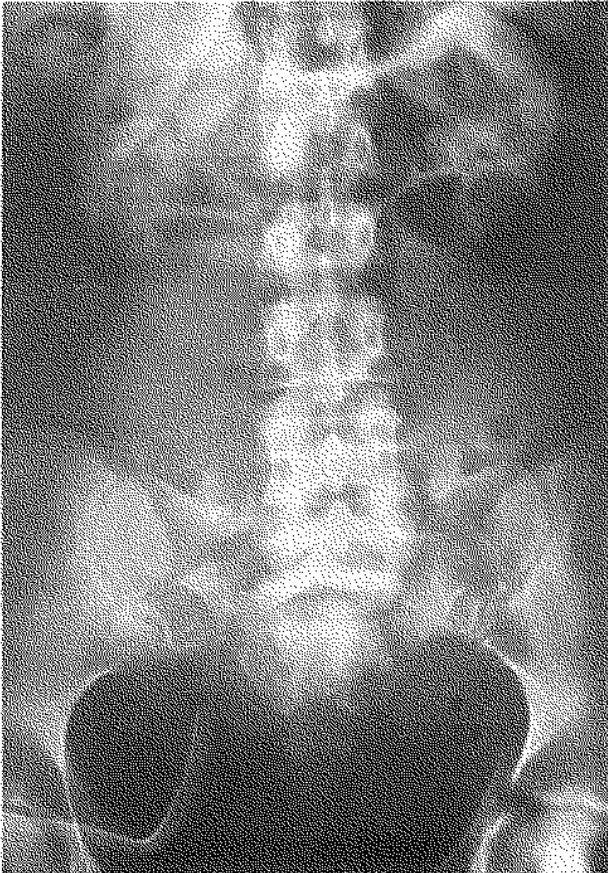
Radiograph of lumbosacral spine. Note the intrusion into the pelvic ring.
